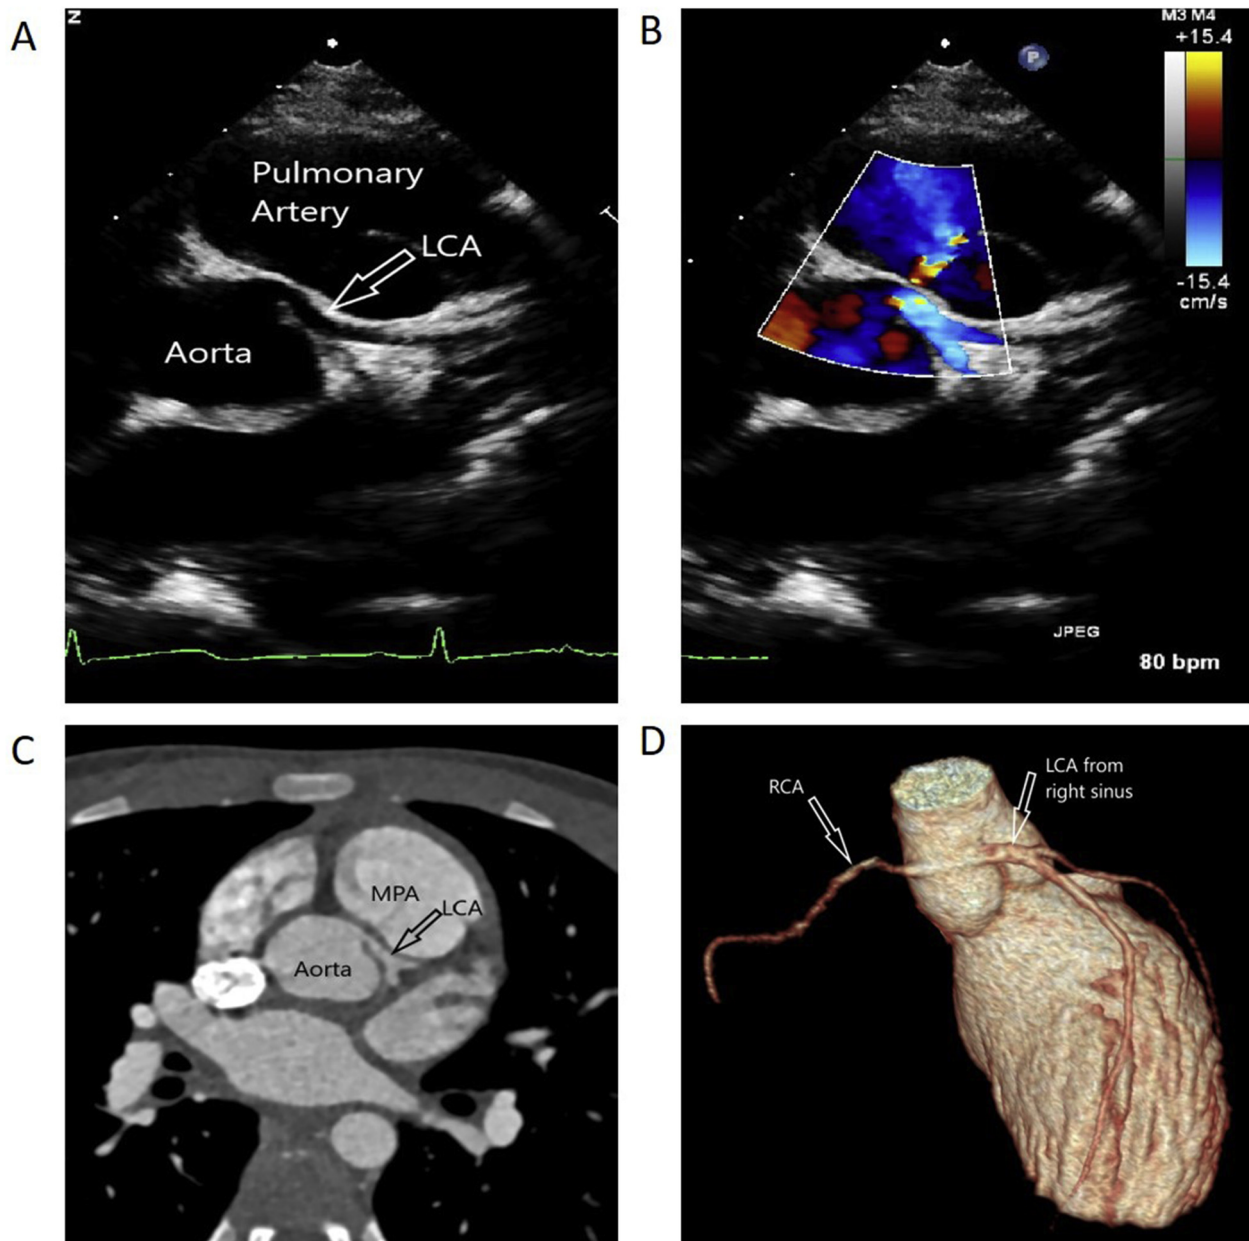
Representative multimodality imaging from a pediatric CA presenting with chest pain and near syncope found to have an underlying high-risk anomalous coronary artery. (A) Transthoracic echocardiographic parasternal short-axis view demonstrating an anterior left coronary origin feeding a long left main coronary artery coursing between the aorta and the pulmonary artery. (B) Color Doppler imaging demonstrating diastolic flow in the proximal left coronary artery. (C) Cardiac CT imaging and 3-dimensional reconstruction (D), confirming origin and proximal course of high-risk anomalous left coronary artery.
